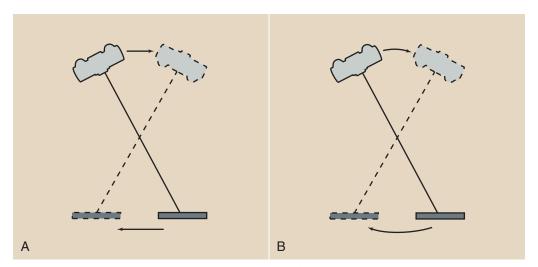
A, Image receptor and tube head of a general-purpose x-ray imaging system designed to move tomographically within a plane. B, An imaging system designed for tomography to move within an arc.
